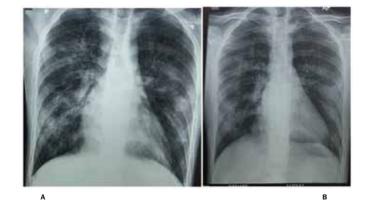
Transient Pulmonary Infiltrates seen in Chest Xray one day apart: A(Before) B(After)
